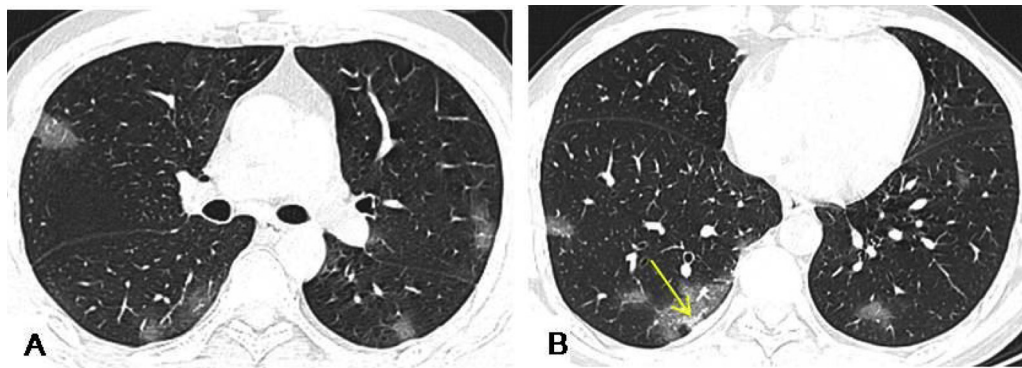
A 48-year-old male presented with a 1-week history of coughing and a 5-day history of fever. HRCT demonstrated multiple patchy or nodular opacity and GGO under the pleura, with poorly defined margins, mostly in the lower lobe of the lung, and a few consolidations in the right lower lobe lesion (yellow arrow).
